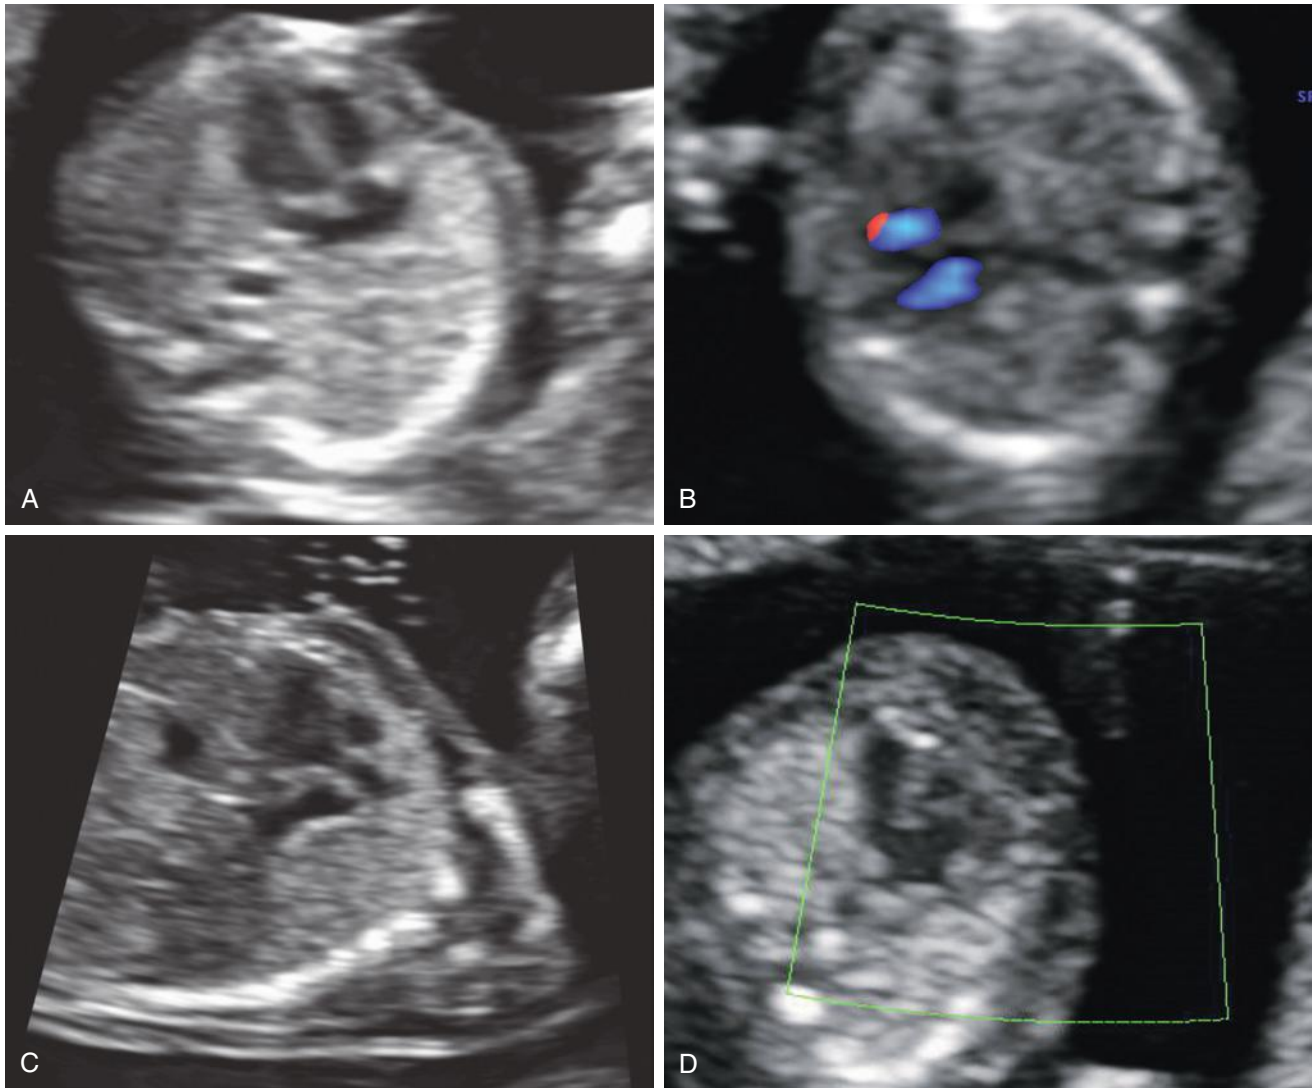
Fetal heart in the late first trimester. A, Four-chamber view of the heart at 14 weeks' gestation. B, Four-chamber view visualized with color Doppler. C, Left ventricular outflow tract. D, Atrioventricular canal defect at 12 weeks' gestation.
